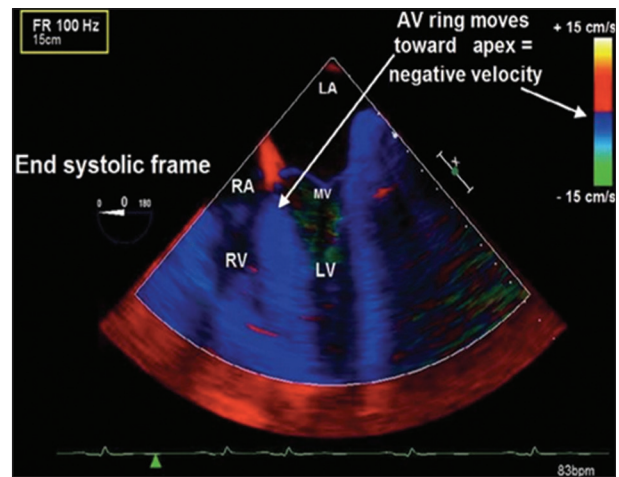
Tissue Doppler imaging of a midesophageal four-chamber view acquired as a full-sector view; frame rate is 100 Hz
